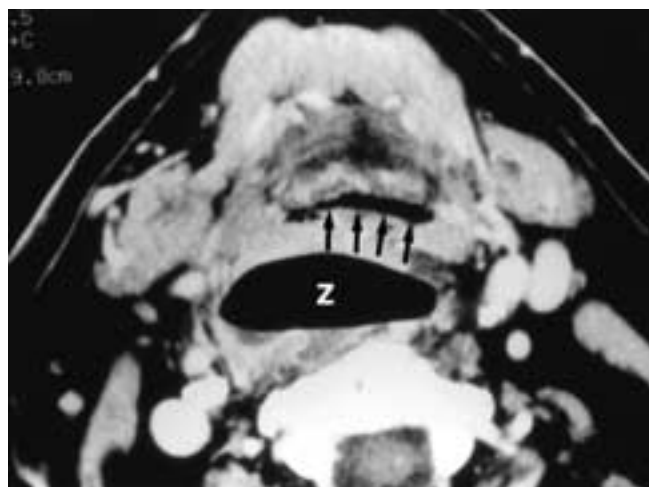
Axial contrast-enhanced CT scan shows a large air-containing cavity posterior to the airway (*arrows*) in a patient with a large Zenker's diverticulum (*Z*).
